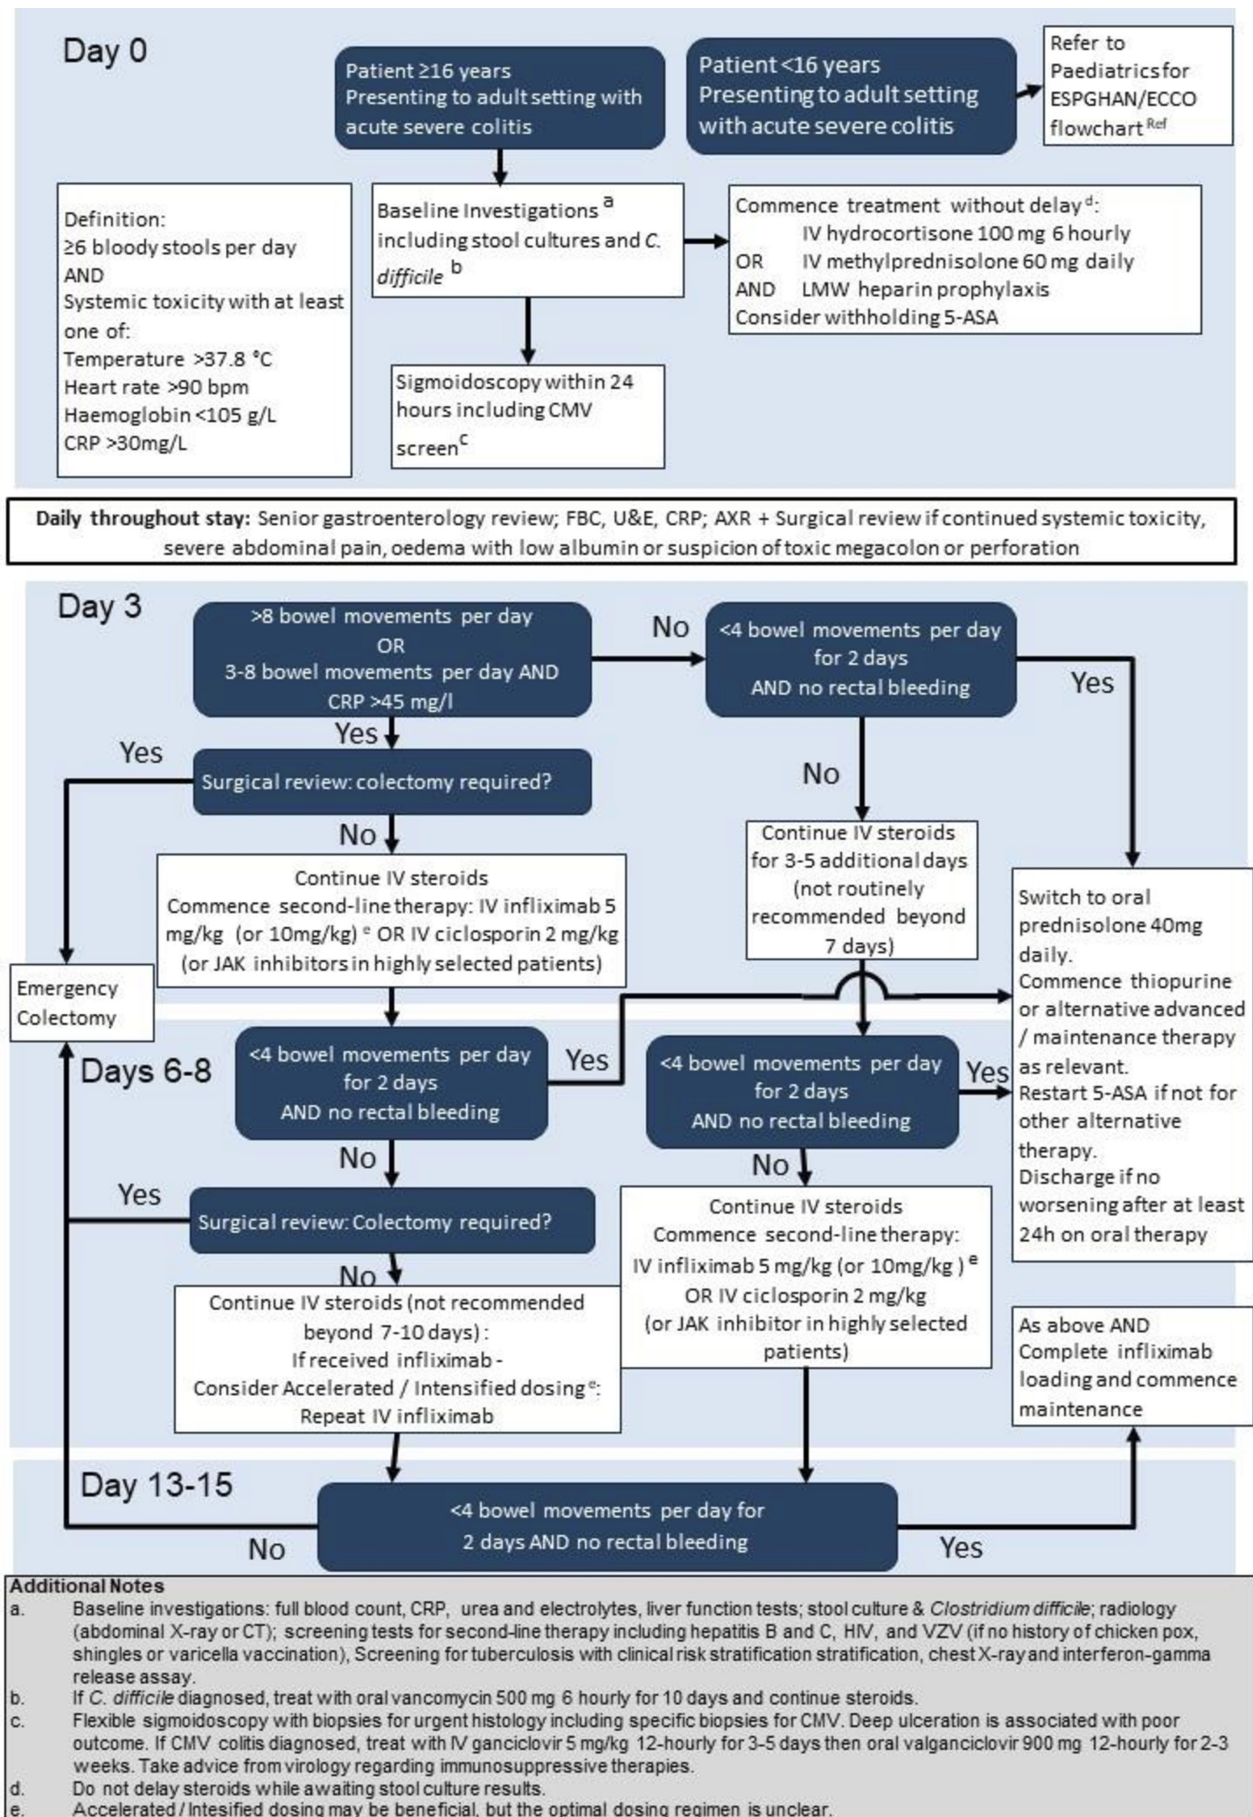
Management of acute severe colitis. 5-ASA, 5-aminosalicylic acid; AXR, abdominal X-ray; CMV, cytomegalovirus.
